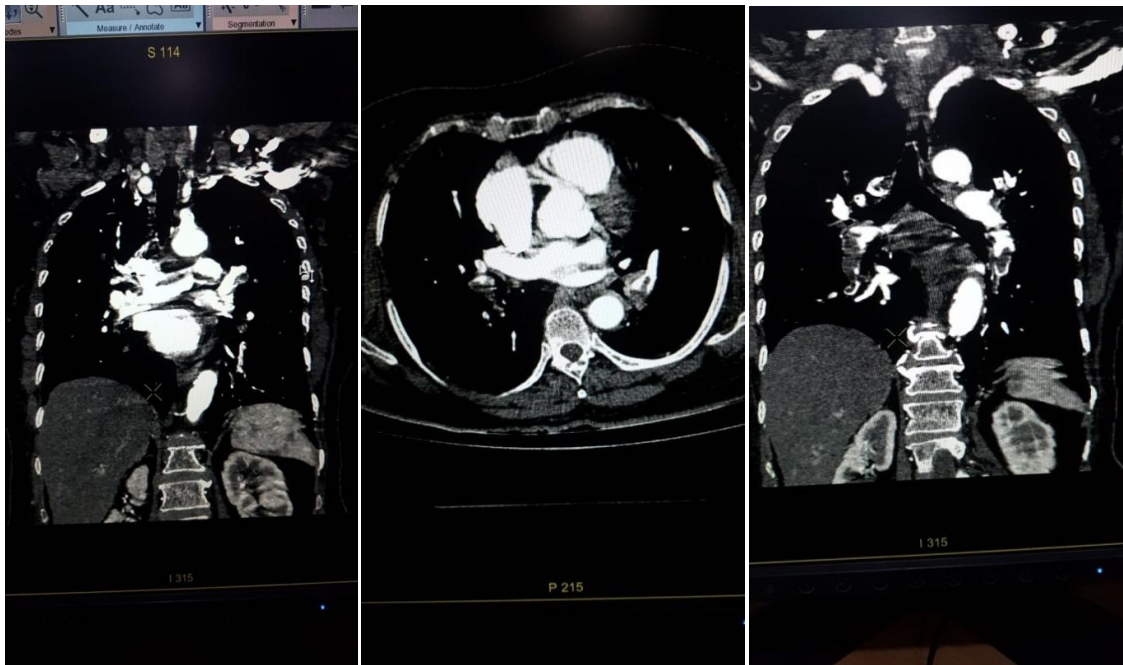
CT pulmonary angiogram showing bilateral partially occluding thrombus in pulmonary arteries
